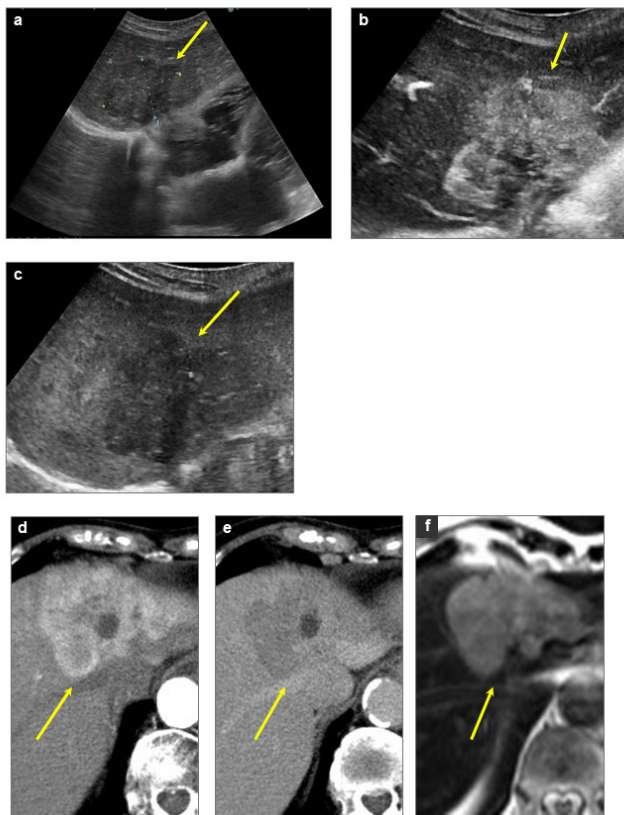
Imaging Findings. (a) US, 40 × 60mm hypoechoic nodule in segment 4. (b) CE-US, hypervascular in the arterial predominant phase. (c) CE-US, defect in the Kupffer phase. (d) CE-CT, hypervascular except for the central region in the early phase. (e) CE-CT, defect in the delayed phase. (f) SPIO MRI, defect on T2-weighted image.
